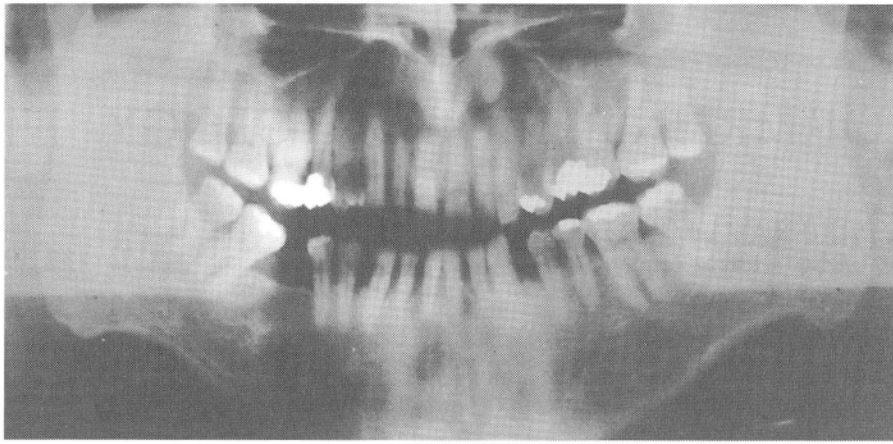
X-ray plain film (orthopan) changes in the alveolar bone could be observed.
